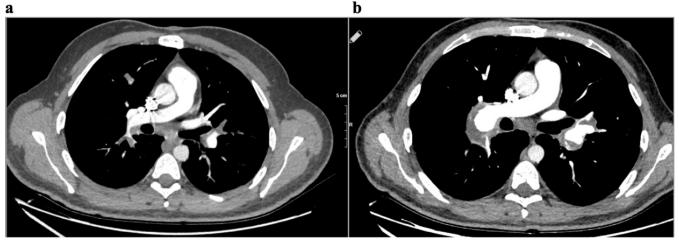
Thorax computed tomography (CT) images of Case 1 before (a) and after (b) tocilizumab therapy.a) Axial contrast-enhanced CT scan shows thrombosis at the right lower and left upper and lower pulmonary arteries before tocilizumab treatment.b) Axial contrast-enhanced CT scan shows bilateral giant saccular partially thrombosed pulmonary artery aneurysms after tocilizumab treatment.
